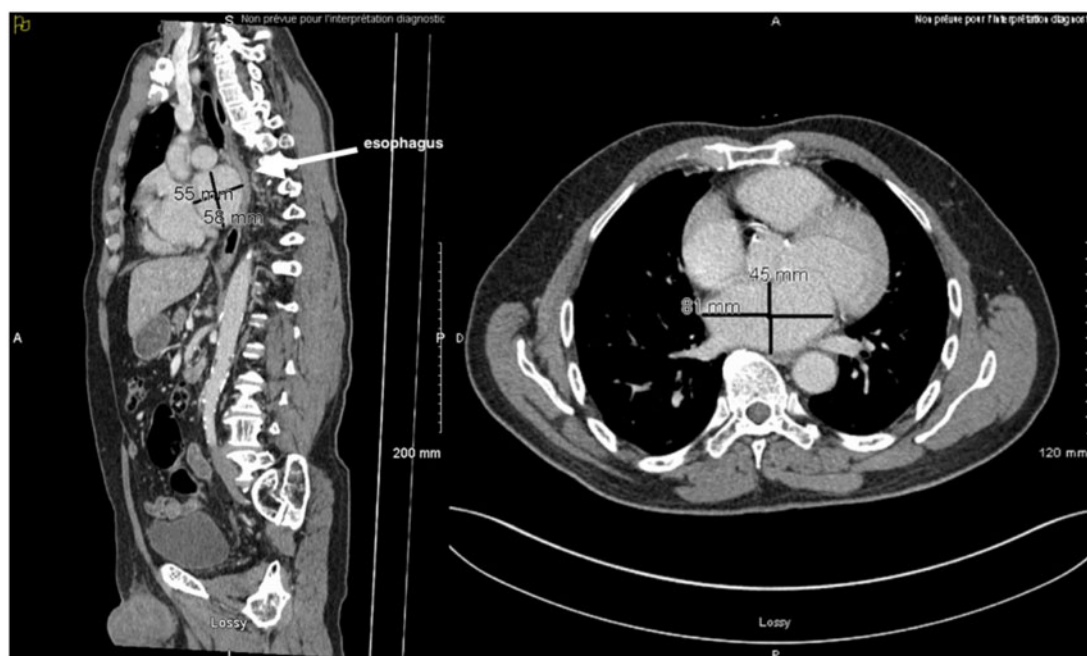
Enhanced chest computed tomography showing an enlarged left atrium compressing and displacing posteriorly the middle oesophagus part.
